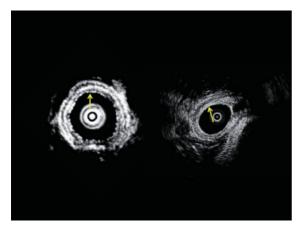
Tips for achieving optimum ultrasound images. Rotation of the EBUS image according to the relative positions of the bronchial tree and the esophagus and great vessels.
